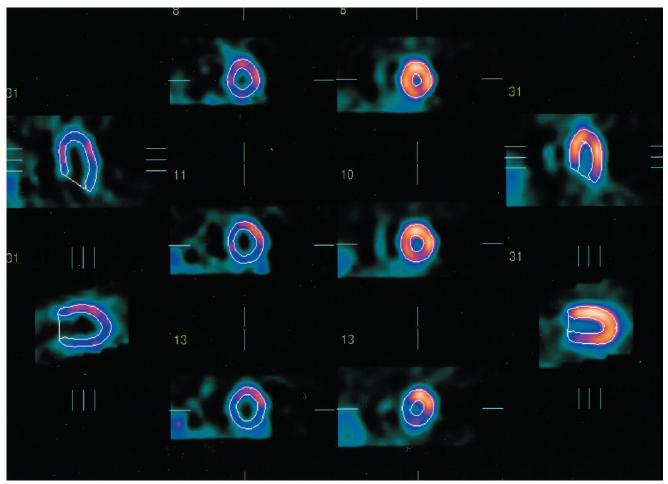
Gated single-photon emission computed tomographic analysis for geometric determination of ejection fraction. Endocardial borders are delineated by "contours," a quality control measure that allows the nuclear cardiologist to verify proper border detection.
